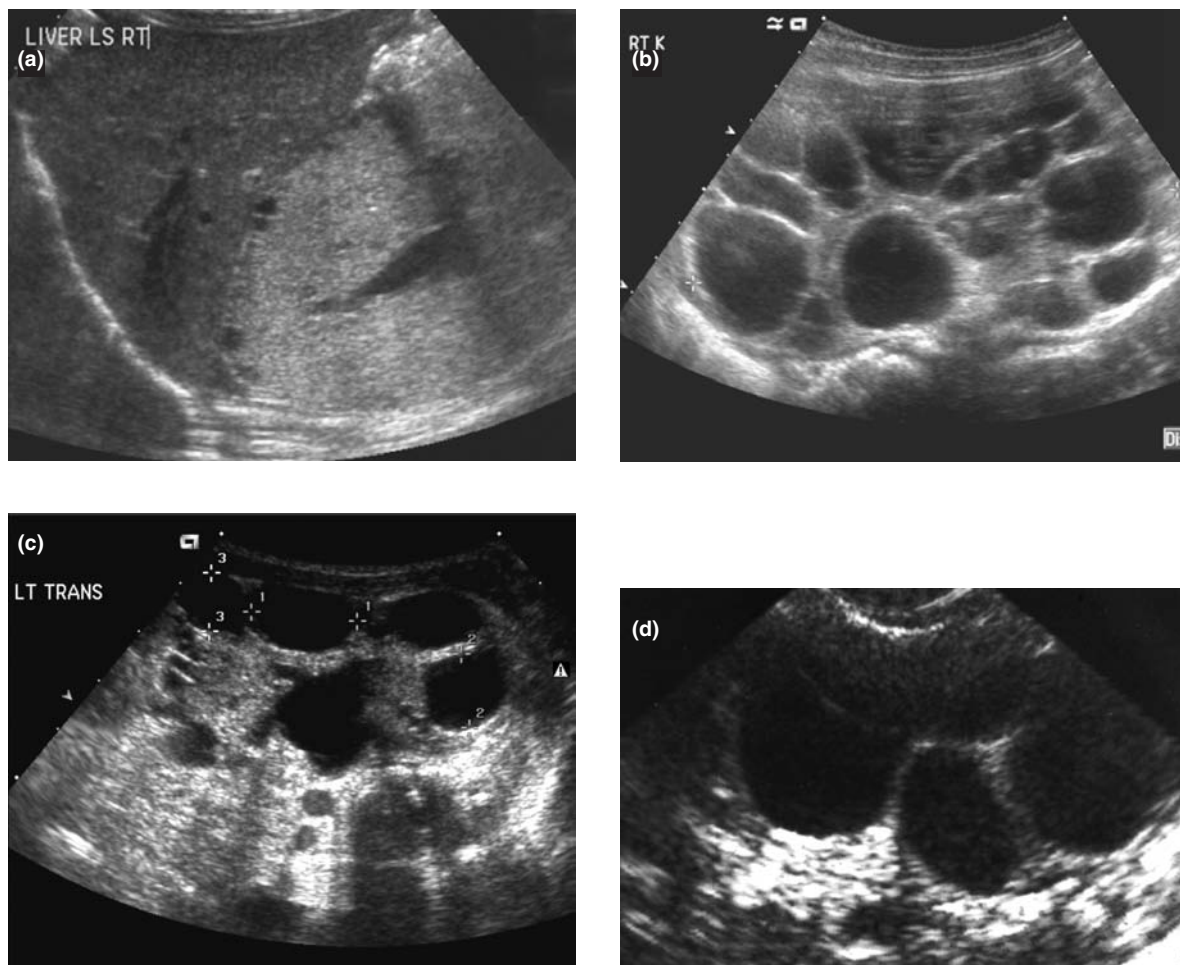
Cystic disease. Ultrasound appearances of (a) autosomal recessive polycystic kidney disease with bright parenchyma and multiple tiny cysts compared with (b) autosomal dominant polycystic kidney disease with multiple large hypoechoic cysts, (c) cystic dysplasia with scattered cysts and (d) multicystic dysplastic kidney with multiple cysts and septa containing no intervening renal parenchyma.
